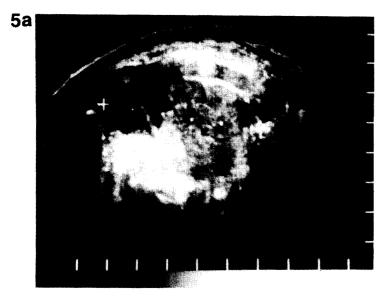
Ultrasonogram of endometrial cyst.
